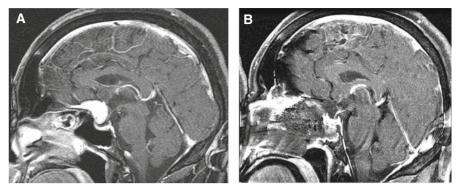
Transplanum approach for tuberculum sellae meningioma. Preoperative (A) and postoperative (B) contrasted sagittal MRI of the brain showing the complete resection of a large tuberculum sellae meningioma
